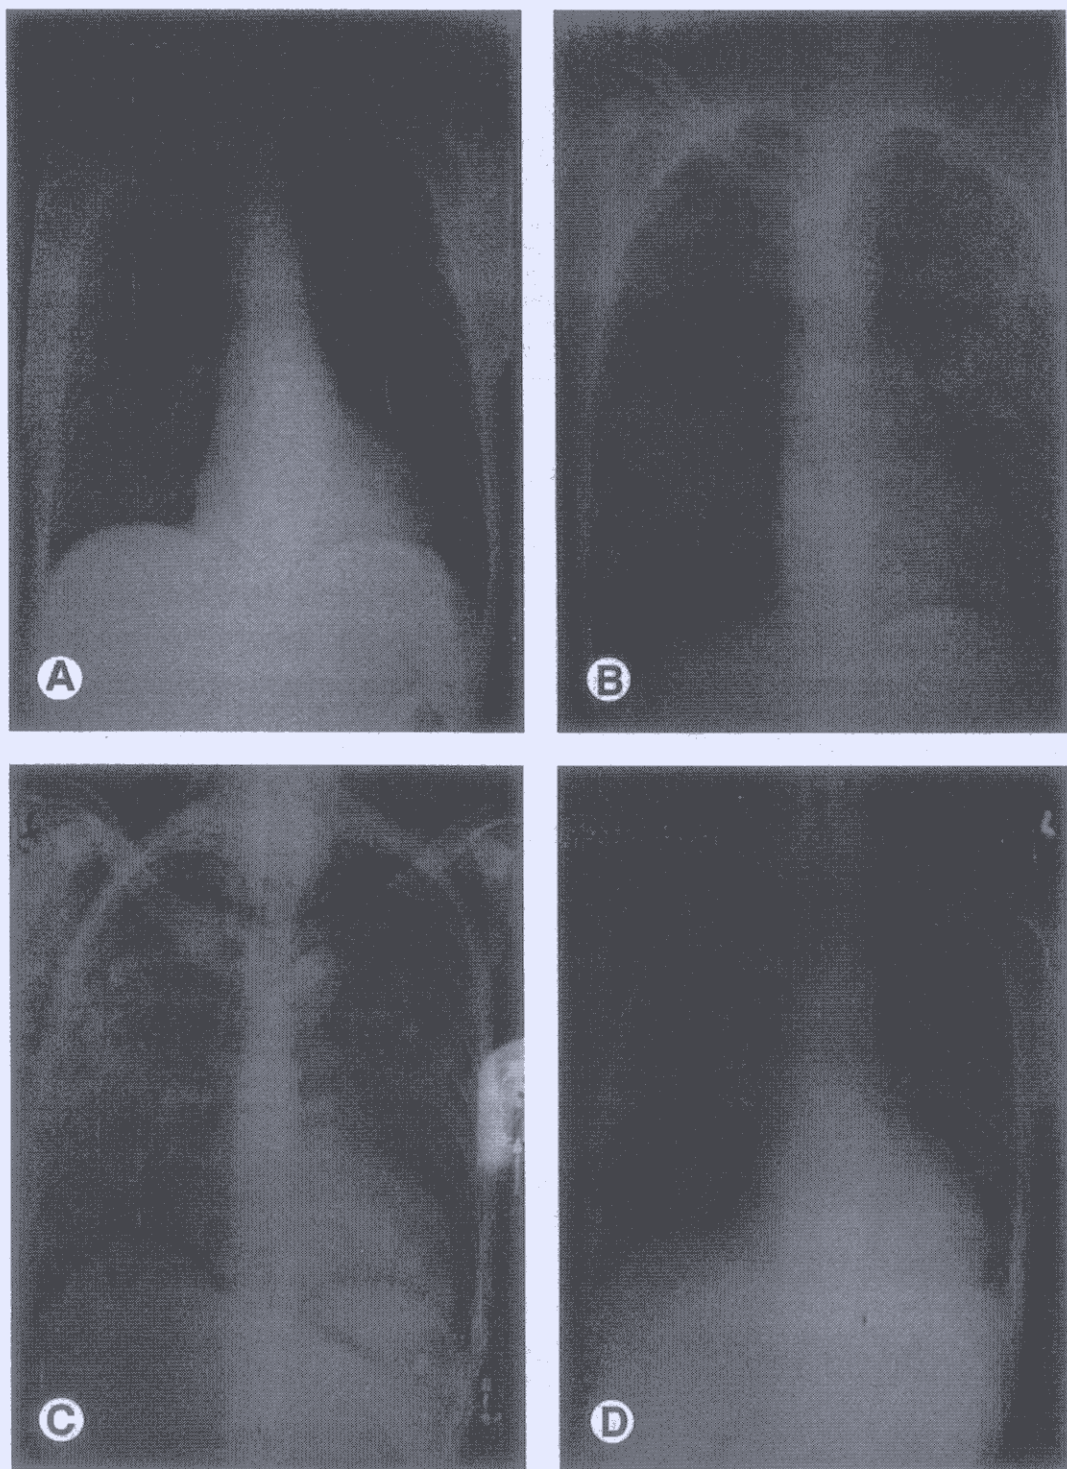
Serial chest radiograph: (A) on initial presentation; (B) 8 days after initial presentation, immediately before the first admission to intensive care unit; (C) 5 weeks after initial presentation, showing persistent bilateral pulmonary infiltrate despite ribavirin and corticosteroid; and (D) 8 weeks after initial presentation, showing slowly resolving pulmonary infiltrate.
